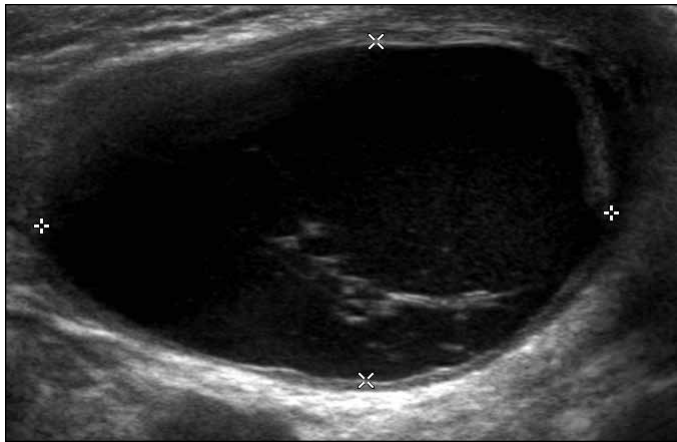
Ultrasonography revealing a near-complete replacement of the right testis by the tumour.
